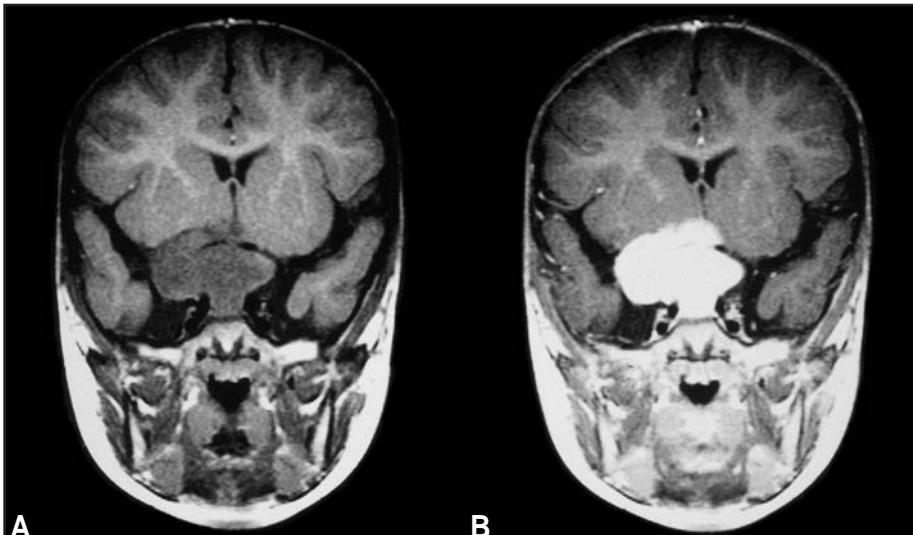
Pilocytic astrocytoma of the optic nerve and chiasm. A Coronal T1-weighted MRI shows a well-demarcated lesion with (B) intense gadolinium (Gd)-enhancement. The tumour causes a compression and shift of the adjacent fronto-basal brain structures.
